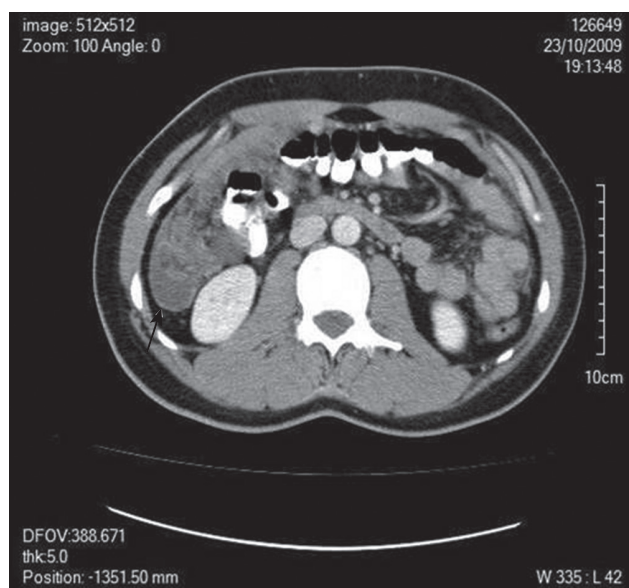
Abdominal CT showing ascites with solid components (arrow).
